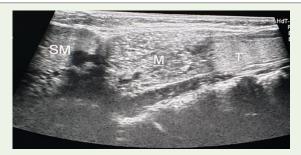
Ultrasonography of right side of neck showing the cervical ectopic thymus between the right submandibular gland and right side of thyroid gland..
